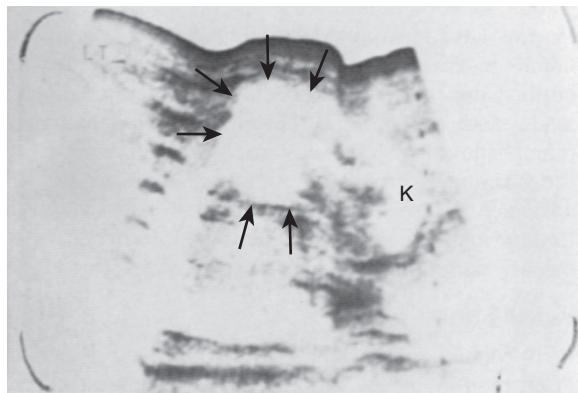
Sagittal gray-scale abdominal ultrasonographic examination of a 4564-g male infant whose mother had gestational diabetes. Problems included fracture of right clavicle, hyperbilirubinemia requiring three exchange transfusions, and abdominal distention with large left flank mass. Ultrasonographic examination at 14 days demonstrated fluid-filled mass (arrows) superior to left kidney (K), representing adrenal hemorrhage. (Courtesy of Dr. John C. McFadden, Lutheran General Children's Hospital, Park Ridge, IL.)
